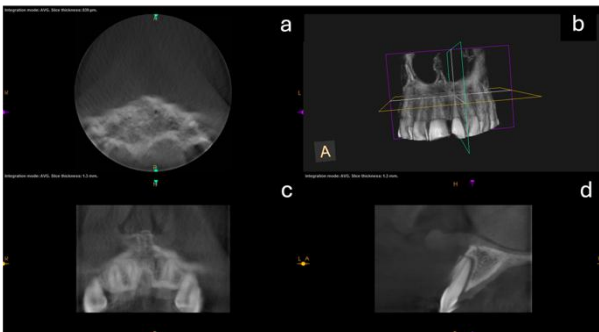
Pre-operative CBCT demonstrating the traumatic defect in the anterior maxilla. (a) Axial slice reveals complete loss of the labial cortical plate and a bucco-palatal ridge width < 1 mm. (b) Volume-rendered view with the re-oriented slicing plane delineates the comminuted labial-plate fracture and buccal displacement of tooth 21. (c) Coronal slice shows vertical loss of the labial plate and over-riding fracture fragments. (d) Sagittal slice through tooth 21 depicts an apical third fracture line and loss of buccal cortical continuity.
